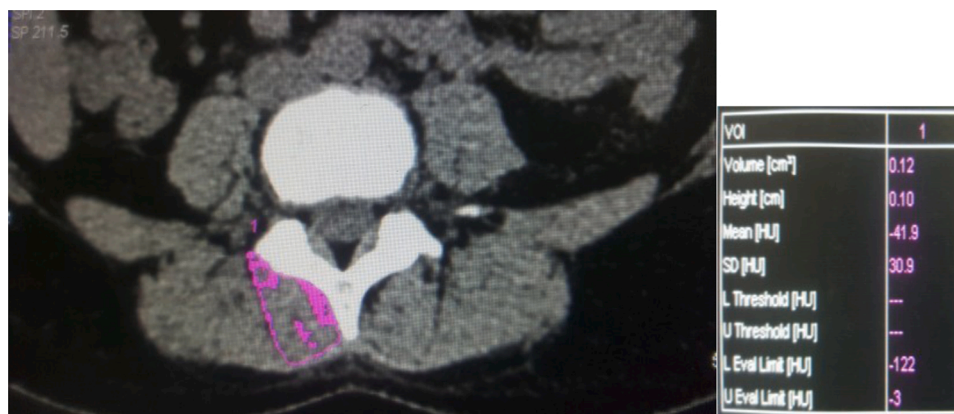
An example of intramuscular fat volume measurement using the software in CT workstation.
